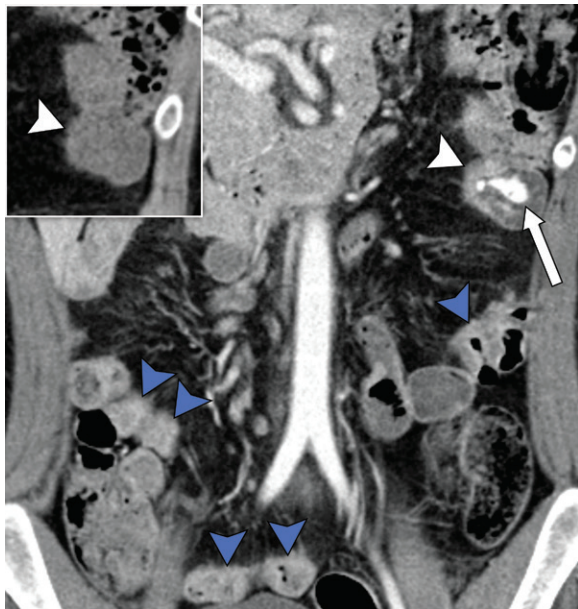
Active inflammatory small bowel Crohn disease with active bleeding in a 29-year-old man who presented with hematochezia and hemodynamic instability. Coronal portal venous phase (main image) and noncontrast (inset) CT images show asymmetric mural thickening and hyperenhancement involving the mesenteric wall of a distal jejunal bowel segment, which are consistent with active inflammatory Crohn disease (white arrowhead in both images) associated with contrast extravasation (arrow). Also noted are multiple additional segments of active inflammation in the jejunum and ileum (blue arrowheads).
